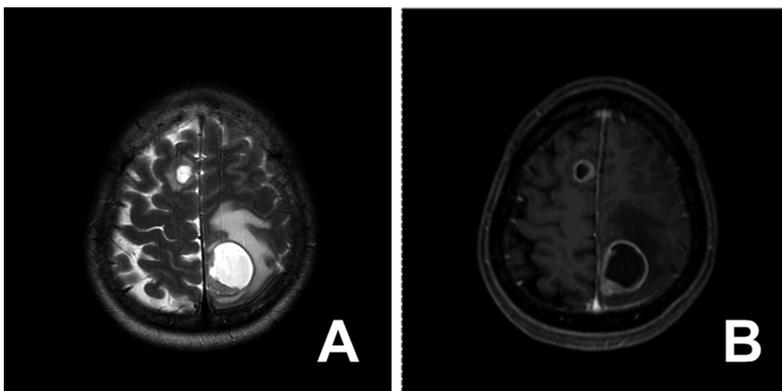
Brain MRI. T2-weighted image (a) and contrast-enhanced T1-weighted image (b) shows multiple tumors with central necrosis and ring enhancement.
